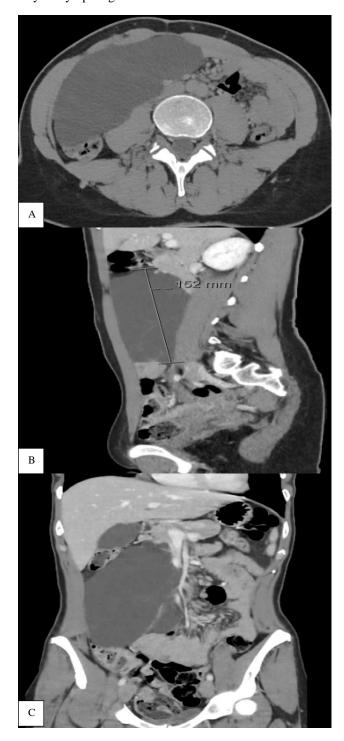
(A-C): Axial, sagittal and coronal CT images of the abdomen with intravenous contrast.
